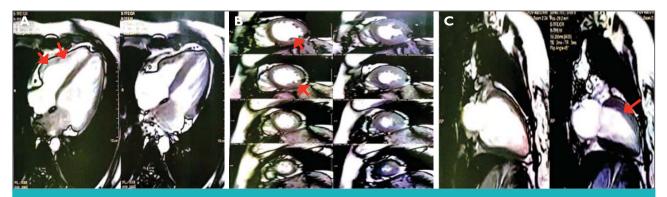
CMR showing global hypokinesia with LVEF 36% (A). MRI-gadolinium enhancement showed small multifocal areas of fibrosis in sub-epicardial region of the left ventricle (B, C) (arrows) with no restriction.
